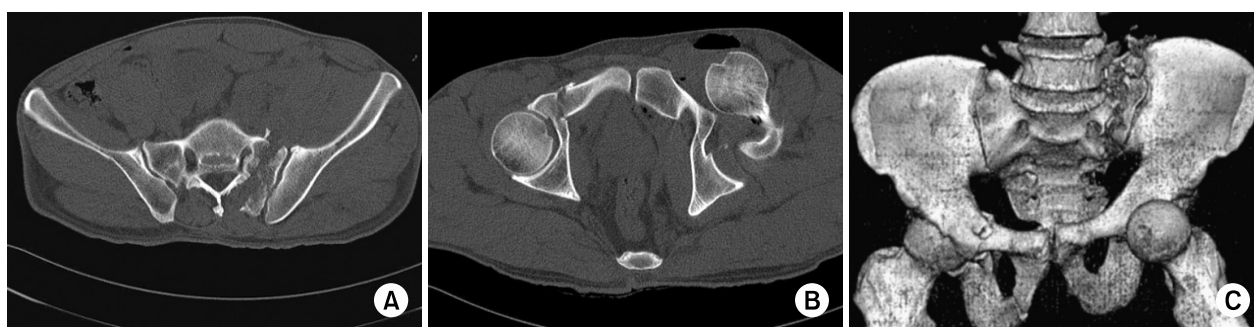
Pelvis CT shows sacral fracture (Type I) (A), anteroinferior dislocation of left femoral head and right pubic fractures (B, C).
